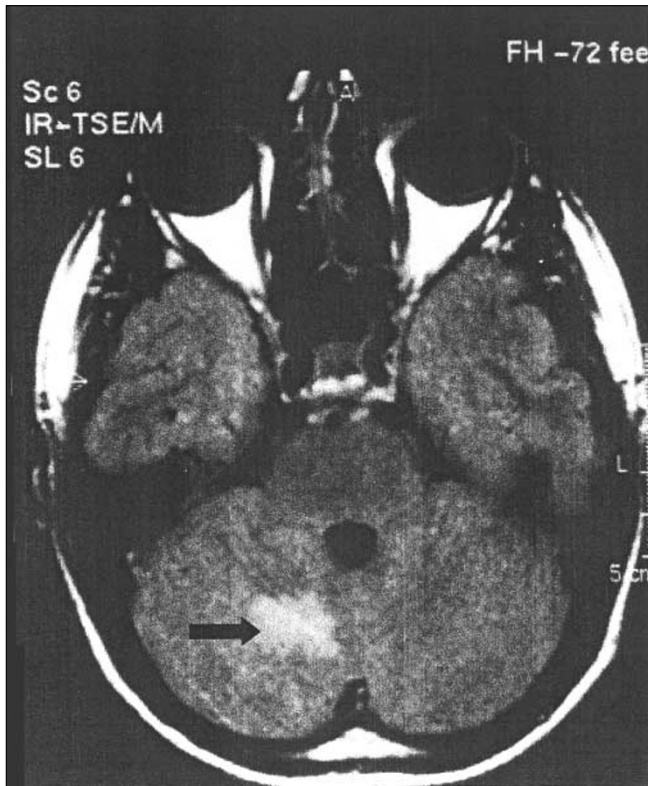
MR image showing an ischemic-like lesion at the cerebellar level (arrow)
